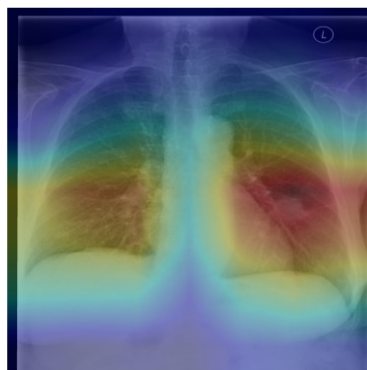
CheXNet outperforms the average of the radiologists at pneumonia detection using X-ray images. CheXNet
